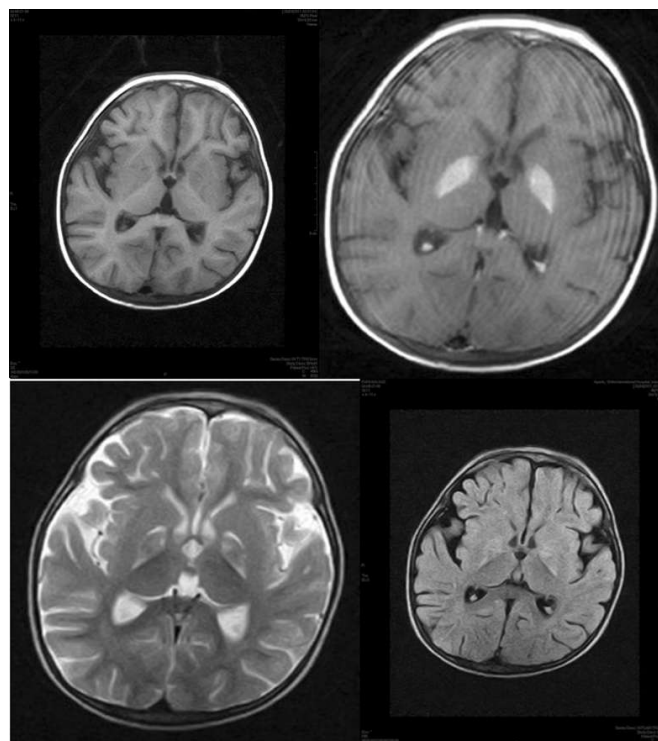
Bilateral symmetrical low T1 and bright flair and T2 abnormality with post contrast enhancement. Abnormal signal in bilateral globus pallidus which is bright on T2 and FLAIR, isointense to hypointense on T1W images and has intense post contrast enhancement.
